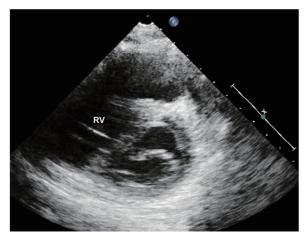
Two-dimensional echocardiography showed enlarged right ventricle (RV), and D-shape of left ventricle.
